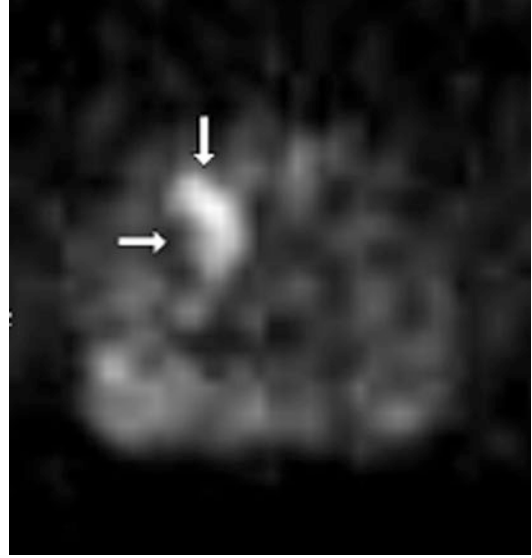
Axial high b -value diffusion-weighted image (DWI)
